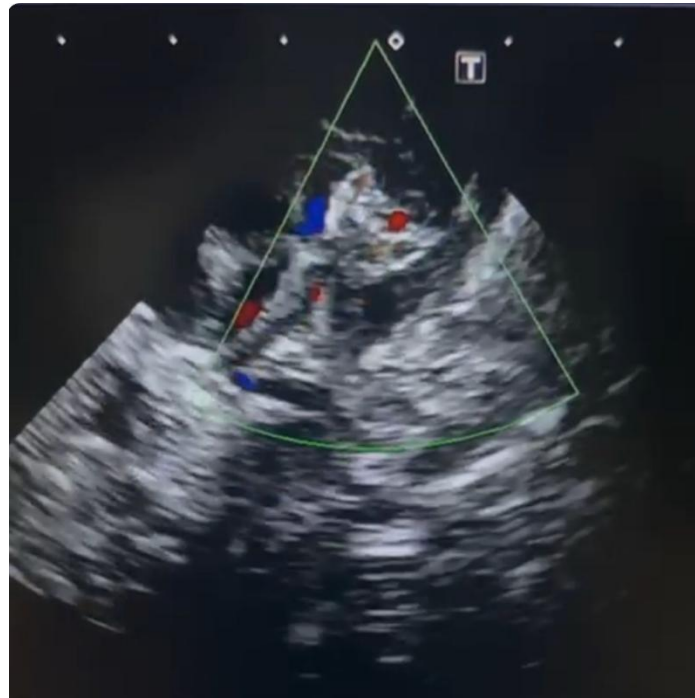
Echocardiogram showing successful deployment of the Piccolo PDA Occluder.
